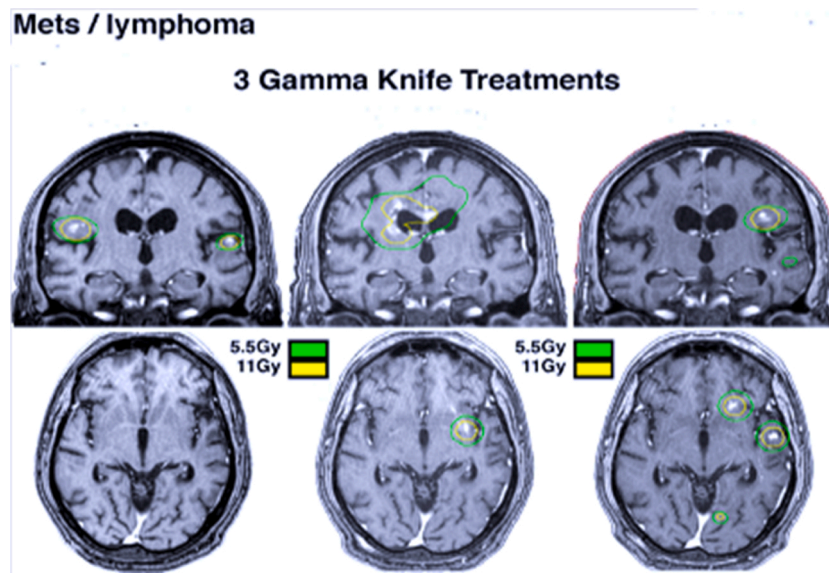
Stereotactic radiosurgery plan, three months, and six-months follow-up. No radiation necrosis is visible in the brain MRI following treatment.
